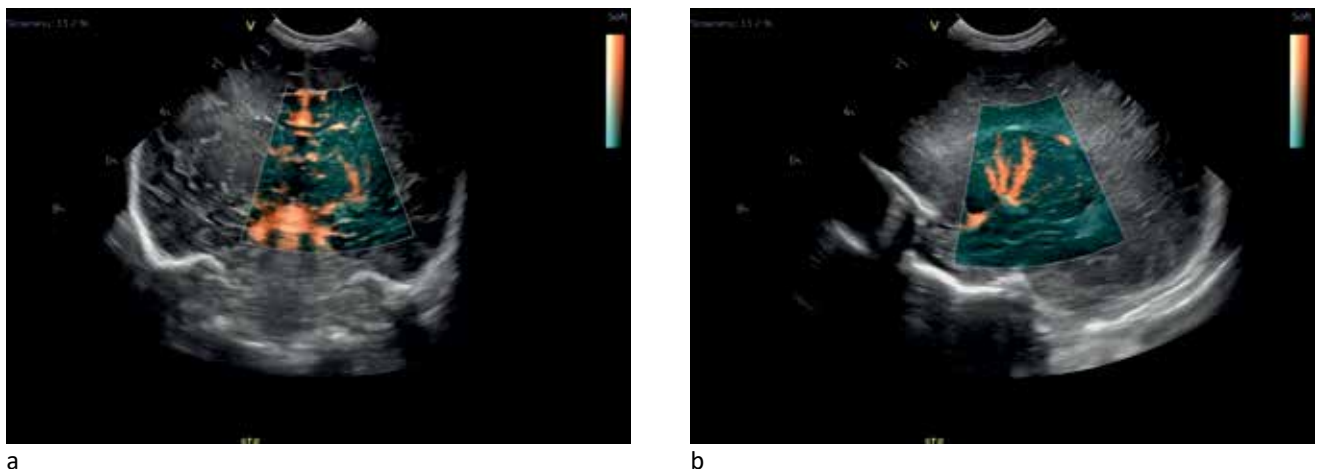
Lenticulostriate vessels – Ultrasound Power Doppler Images – Observe origin from the middle cerebral artery
